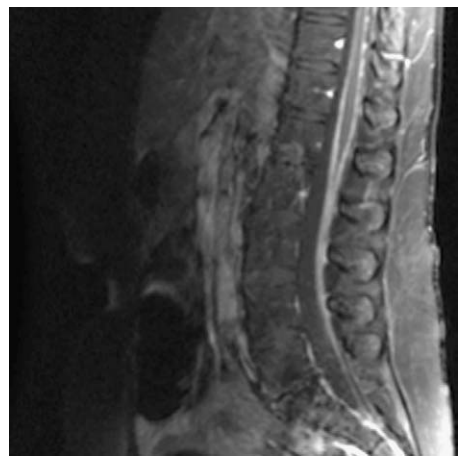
Sagittal T1-weighted image after intravenous contrast with fat saturation shows thick smooth pial enhancement of the terminal cord and conus correlating with leptomeningeal breast cancer metastasis.
